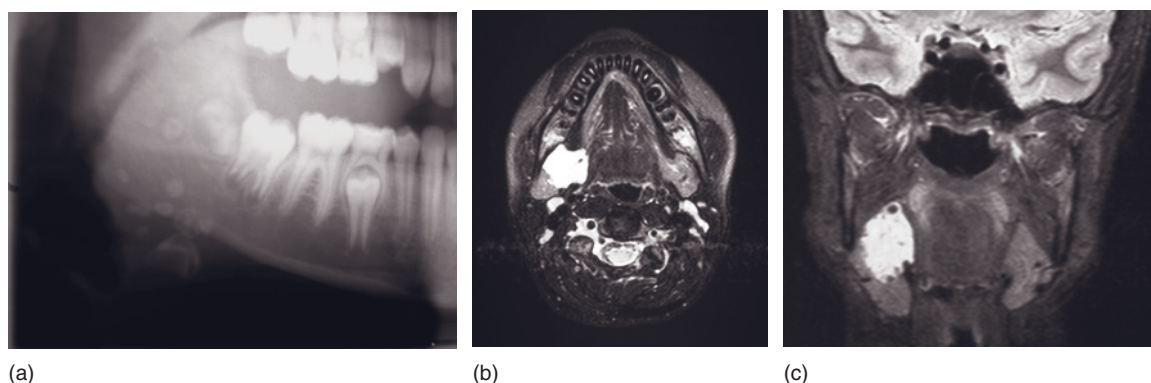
(a) Part of a panoramic radiograph showing several circular radio-opacities produced by phleboliths. Axial (b) and coronal (c) magnetic resonance imaging scans of the same patient showing a high signal lesion lying between the medial pterygoid muscle and the submandibular salivary gland. The signal voids are produced by the phleboliths.
